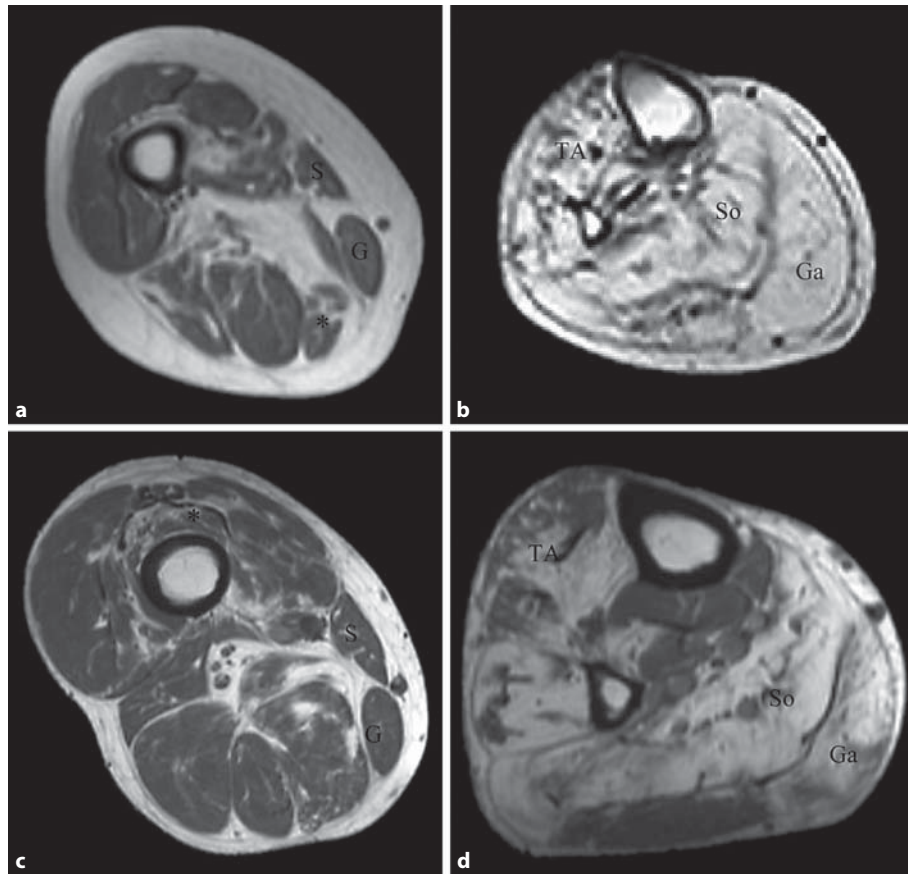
T₁ MRI images from cases of myotilinopathy. a Axial image at mid-thigh from an 81-year-old woman (Patient E) with predominantly distal lower limb weakness. Note fatty infiltration of semi-membranosus (*), with sparing of gracilis (G) and sartorius (S). b Axial image at mid-calf from Patient E. Note extensive fatty infiltration of gastrocnemius (Ga), soleus (So) and tibialis anterior (TA). c Axial image at mid-thigh from a 68-year-old man (Patient D) with predominantly distal lower limb weakness. Note mild fatty infiltration of vasti (*), with sparing of sartorius (S) and gracilis (G). d Axial image at mid-calf from Patient D. Note fatty infiltration of medial gastrocnemius (Ga), soleus (So) and tibialis anterior (TA).
